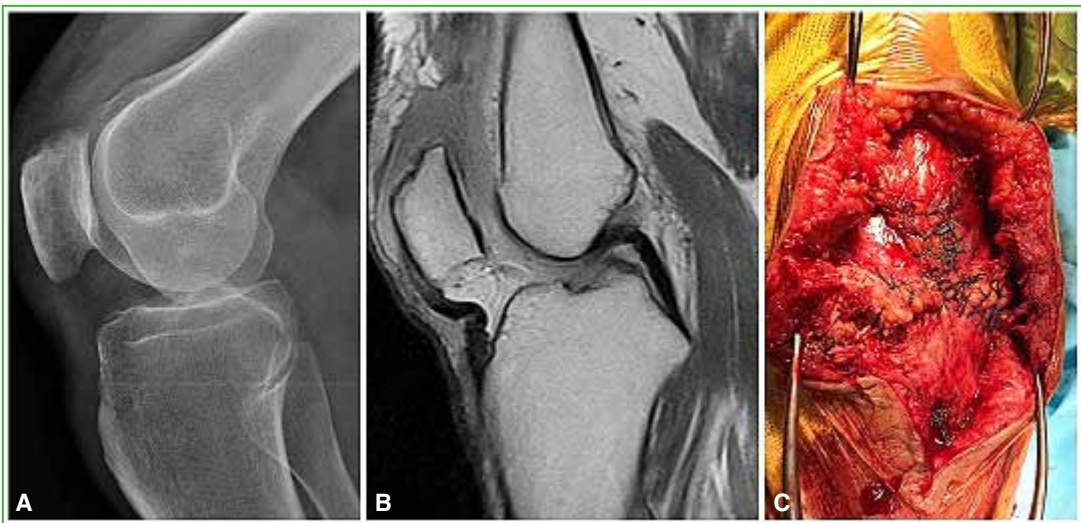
A 74-year-old man with a ruptured quadriceps tendon at its insertion in the patella, who underwent repair by transosseous suture. A. Lateral knee radiograph showing inferior patellar displacement. B. Knee MRI, sagittal plane. The rupture of the quadriceps tendon is observed at the level of its insertion in the patella. C. Immediate postoperative period.
